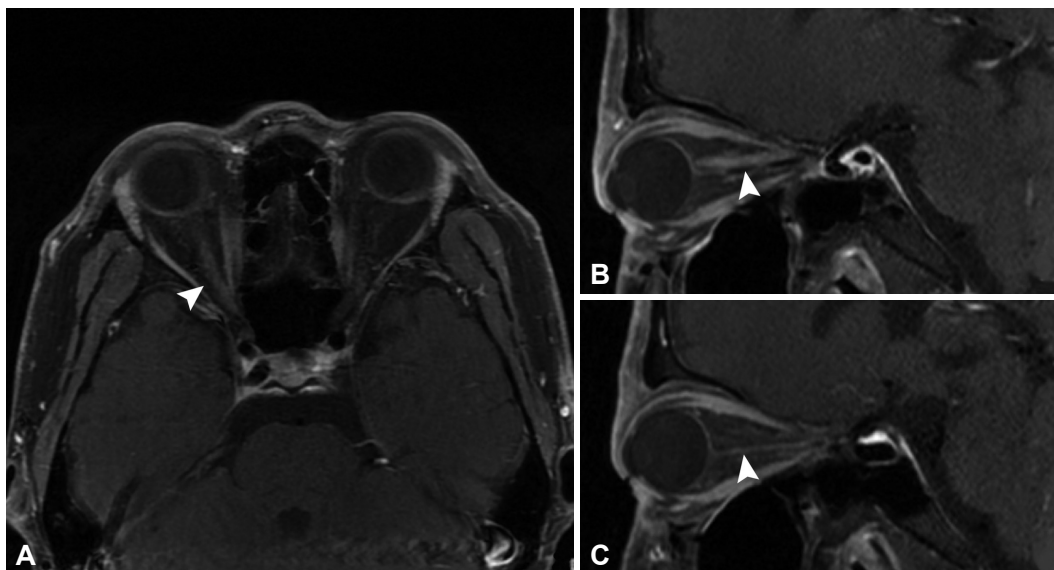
MRI in May showed the enhanced lesion in the optic nerve (arrowheads) of the right eye (A and B), while the left side was normal (C).
